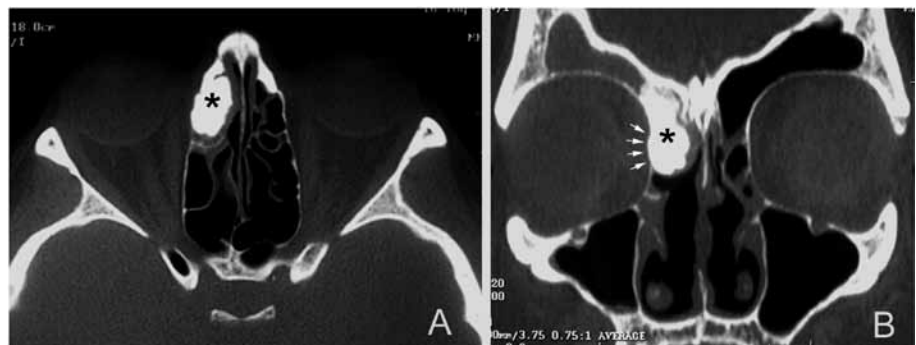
Preoperative CT scan of case 1 shows an osteoma (asterisk) occluding the right frontal recess. Note the remodelled lamina papyracea (arrows) and the lesion attachment over the posteroinferior aspect of the frontal sinus. Axial (A) and coronal (B) plane.
